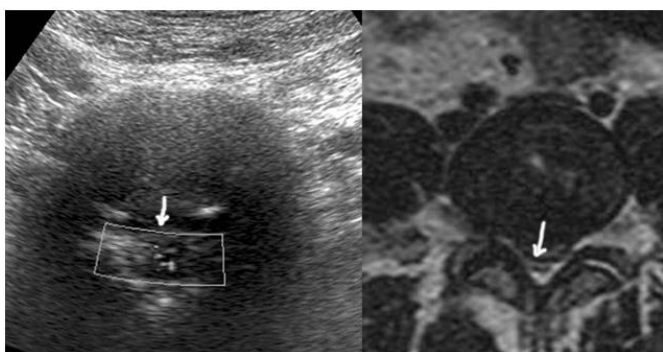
The large sequestering median hernia with severe spinal stenosis is detected by ultrasonography and MRI (arrows).
